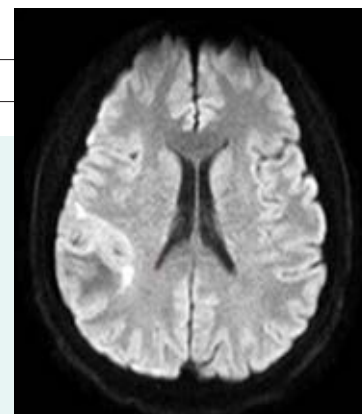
Axial diffusion weighted MRI of brain
